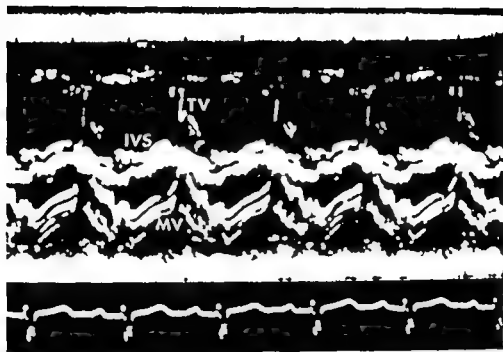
Echocardiogram in the mitral beam direction. The beam passes from the mitral valve (MV) to the posterior wall of the left atrium. The multiple systolic echoes of the mitral valve during systole and simultaneous recording of the mitral valve and the tricuspid valve (TV) are characteristic of ECD. The trace of TV is less continuous than that of MV. The diastolic motion of MV is somewhat distorted. The features to show right ventricular volume overload are also included.
